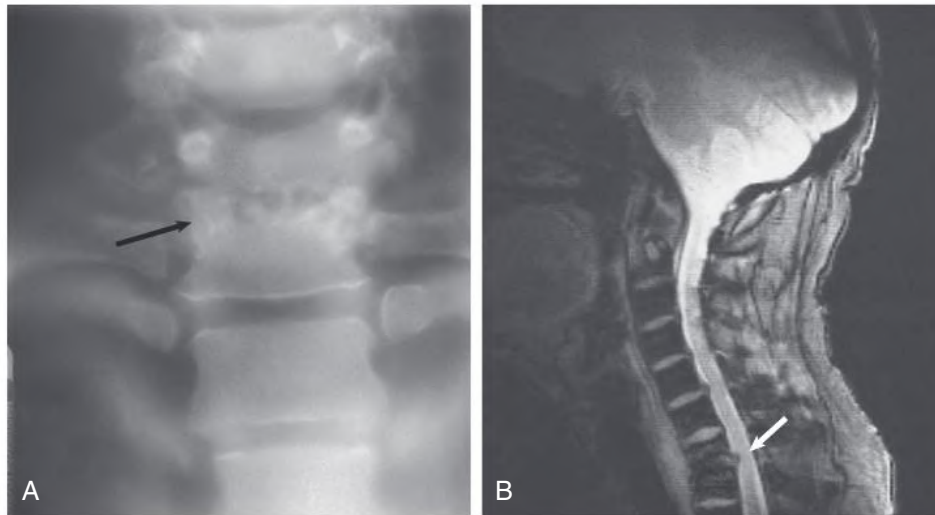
β_2 -Microglobulin ($A\beta_2M$) Amyloidosis–Associated Spondyloarthropathy. (A) Destruction of an intervertebral disk (arrow) in the neck vertebrae of a long-term hemodialysis patient. (B) Magnetic resonance image of the same patient. Note destruction of the intervertebral space and protrusion of material into the spinal canal (arrow).
